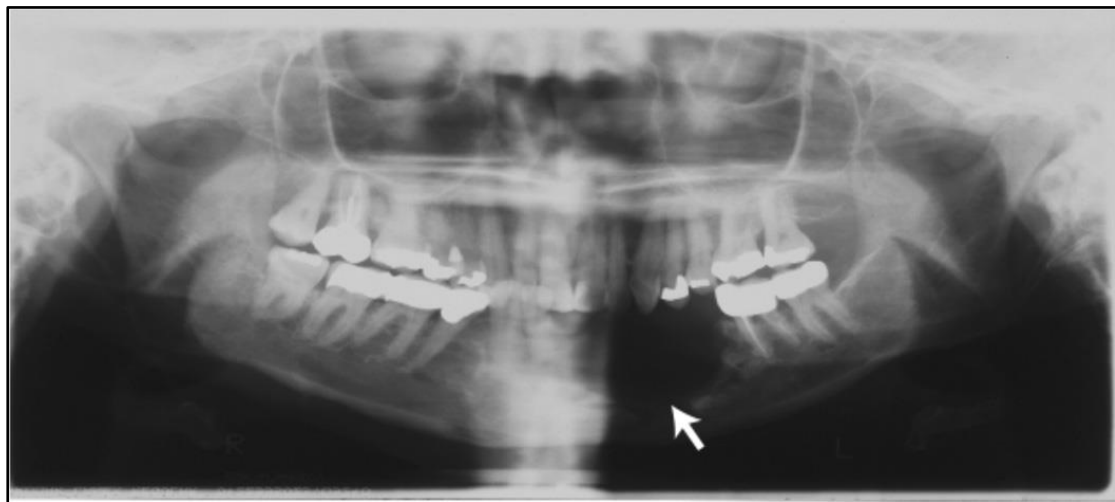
Osteoradionecrosis: Panoramic radiograph shows osteoradionecrosis that developed in the left mandible (white arrow) within the first year of oral cancer radiotherapy, (Marx RE.1983).
